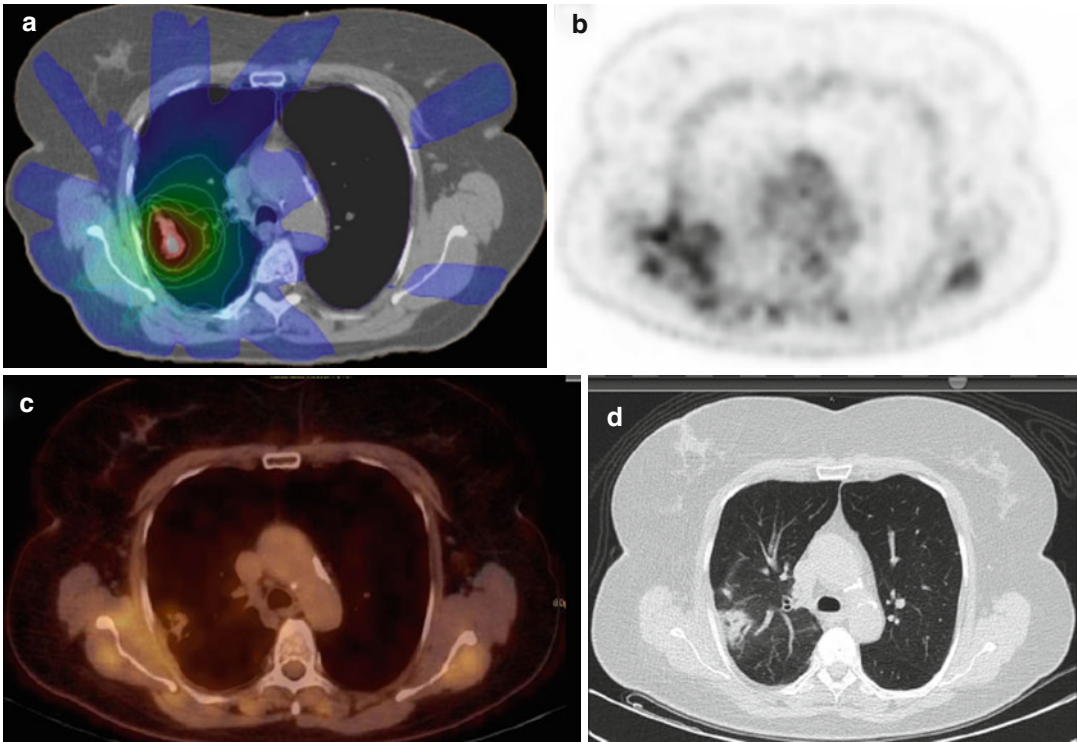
Imaging after SBRT in a patient with localized NSCLC UICC stage I. (a) Isodose distribution of SBRT treatment. (b–d) FDG-PET/CT (b: FDG-PET, c: fused image, d: CT) 1 year after treatment showing diffusely
